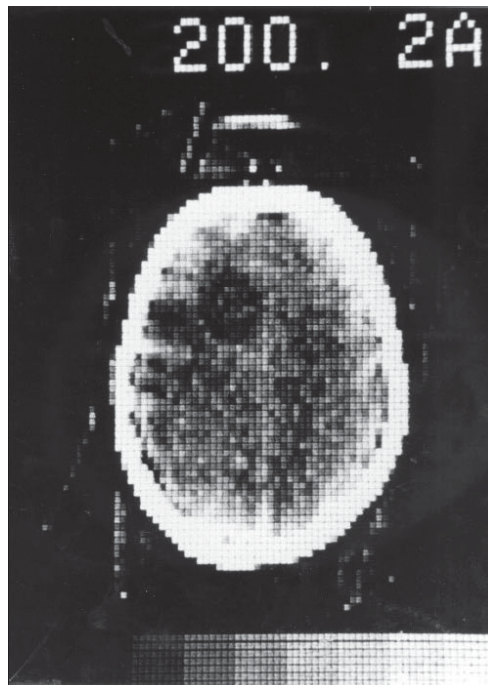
The first CT image [12]: note that for the first time in a X-ray exam of the head the skull is not the only visible part
